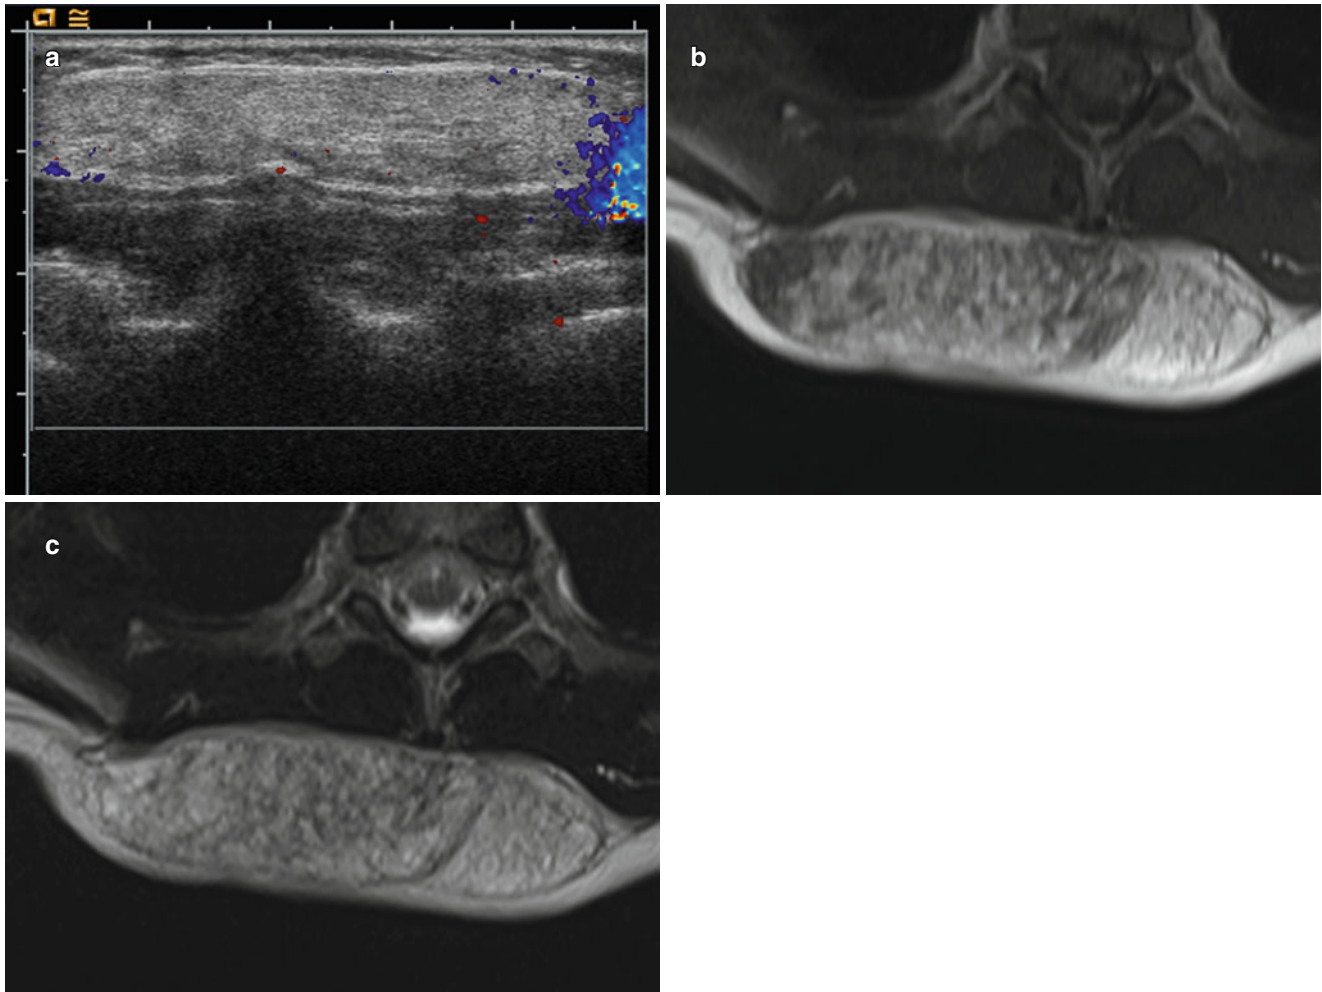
Lipoblastoma in a 2-year-old girl. (a) Color Doppler US shows a hypovascular, echogenic solid mass in the right lower posterior neck extending to the back. (b) Axial T1-weighted image shows a well-defined mass of mixed high and iso signal intensities. (c) Axial
